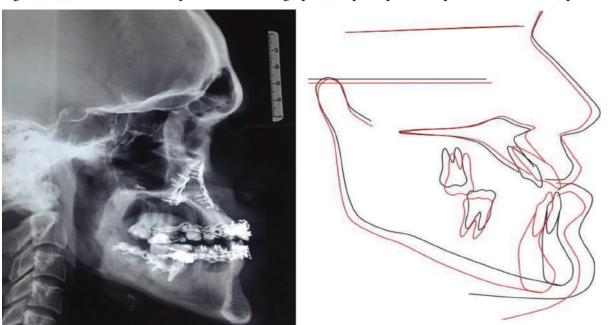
(a) Post-Surgical Cephalometric Radiograph (b) Superimpositions: post distraction (black) and post-surgery (red).
